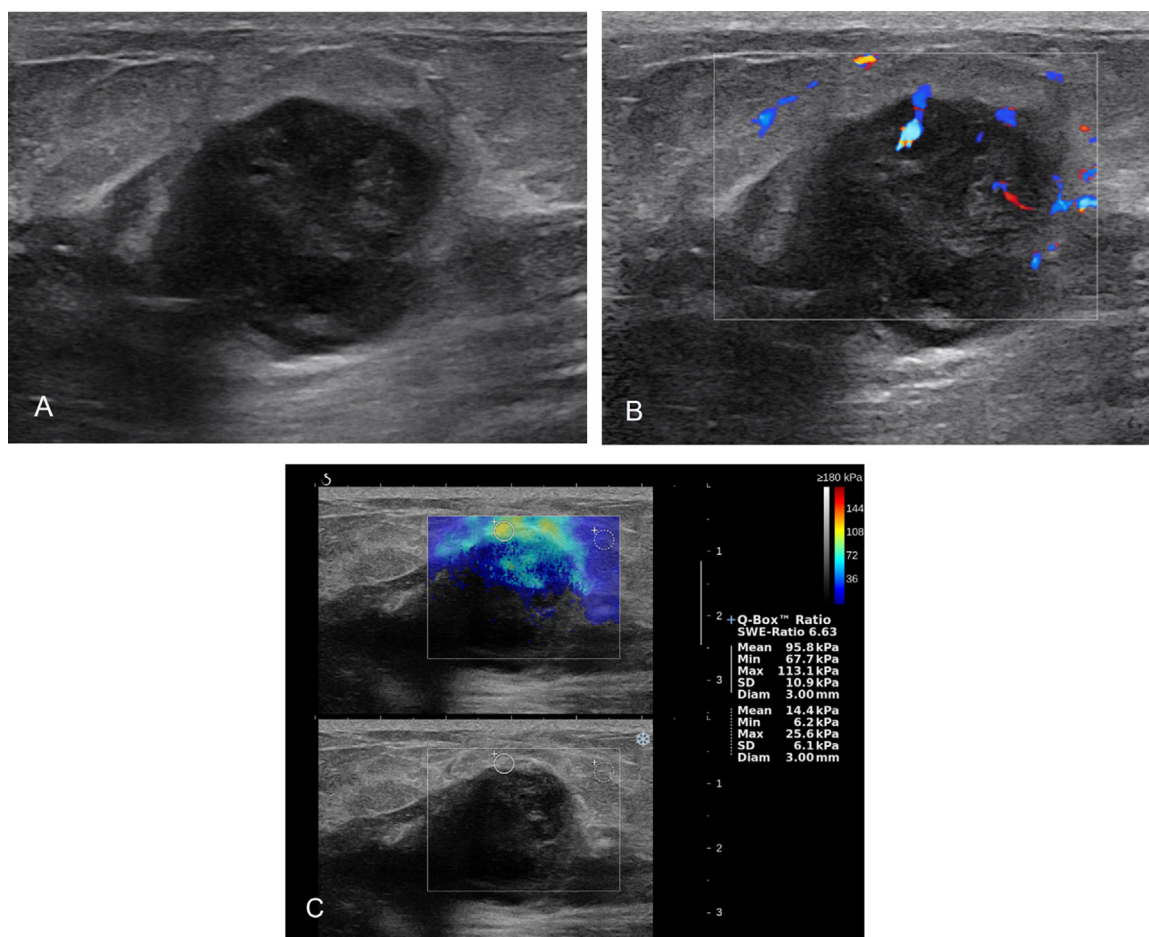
US of a 67-year-old woman with breast lymphoma (same patient as in Fig. 3). (A) Conventional US shows an irregular hypoechoic mass with circumscribed, partially indistinct margins and posterior acoustic enhancement in upper center area of right breast. (B) Color Doppler imaging shows vessels in the peripheral portion of mass. (C) SWE image shows E_{\max} of 113.1 kPa, E_{mean} 95.8 kPa, and mean elasticity ratio of 6.63.
